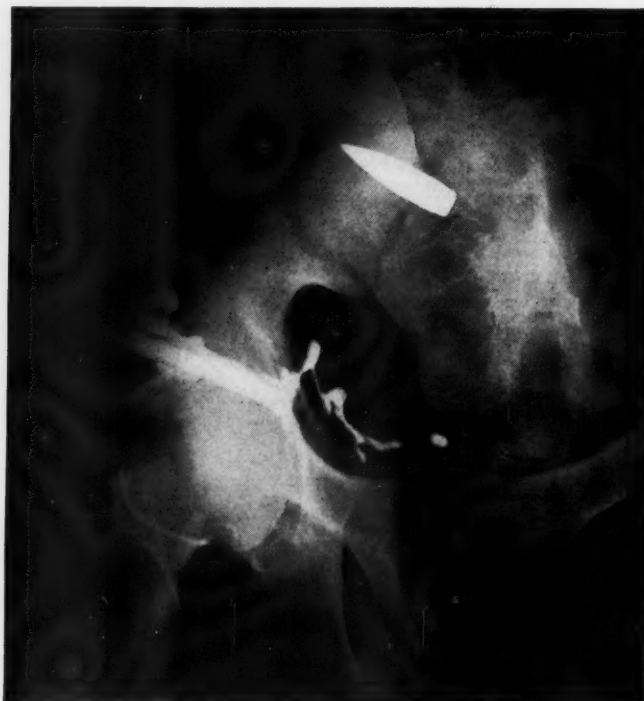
Anteroposterior radiograph after lipiodol injection of right inguinal incision showing upward extension along right iliac fossa and downward to the perirectal space.
